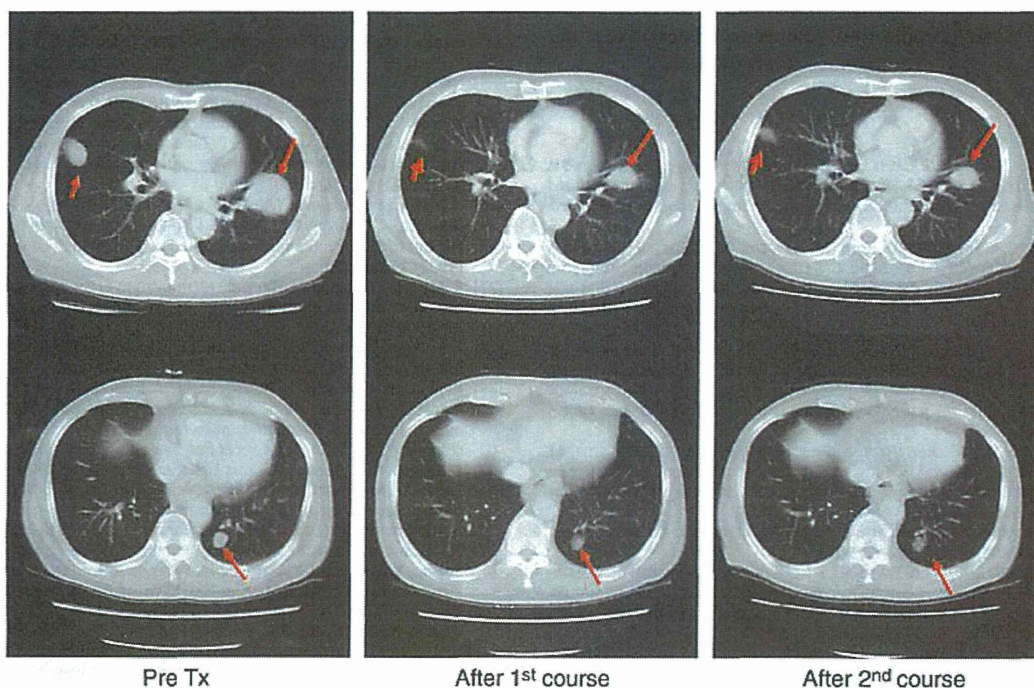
Computed tomography scan of a patient with conventional-chemotherapy-refractory esophageal cancer with multiple pulmonary metastases showing a reduction in tumor burden after two cycles of NK012 at a dose level of 28 mg/m² and continuing study therapy for 5 months until disease progression.
